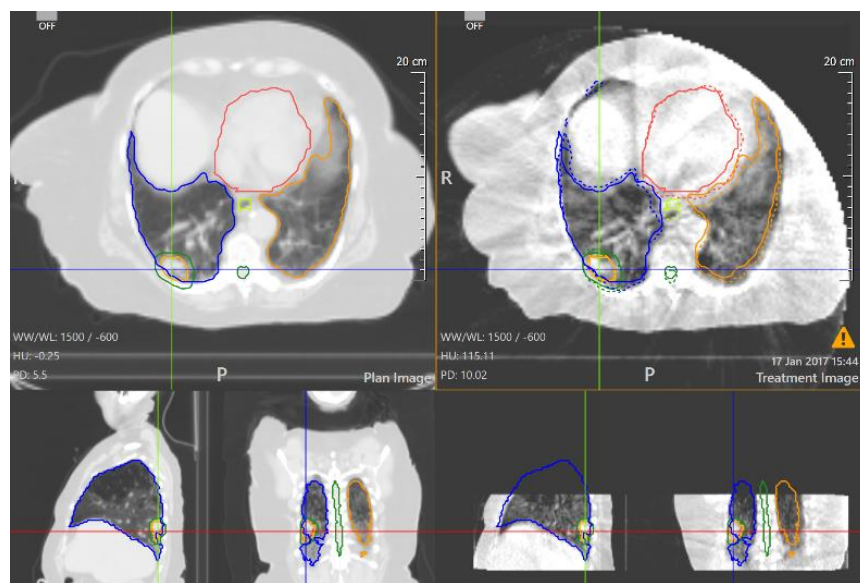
Misalignment of daily CBCT (right) of patient RTAT 74FE in fraction 5.
